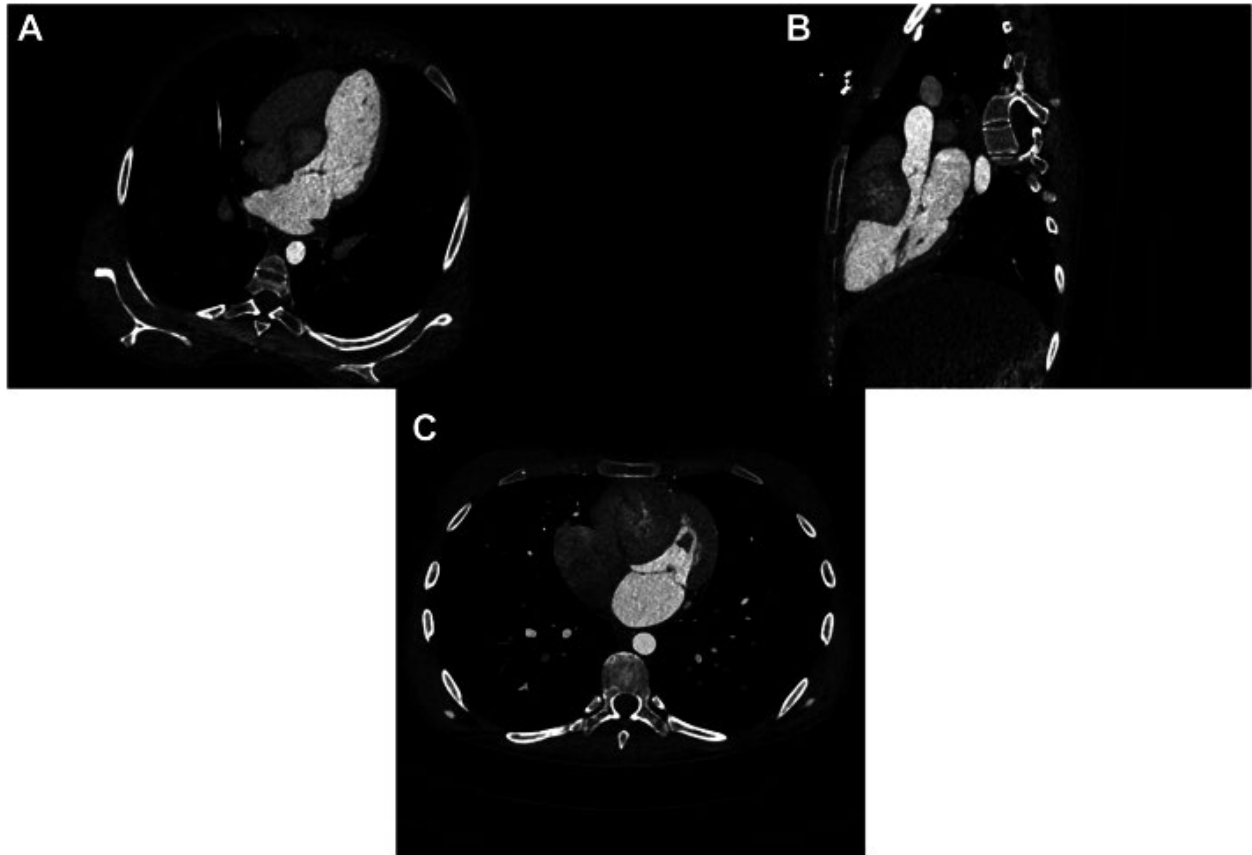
CT image of the IVS mass: A- 4-chamber view; B- left ventricular long axis, C- short-axis view.
